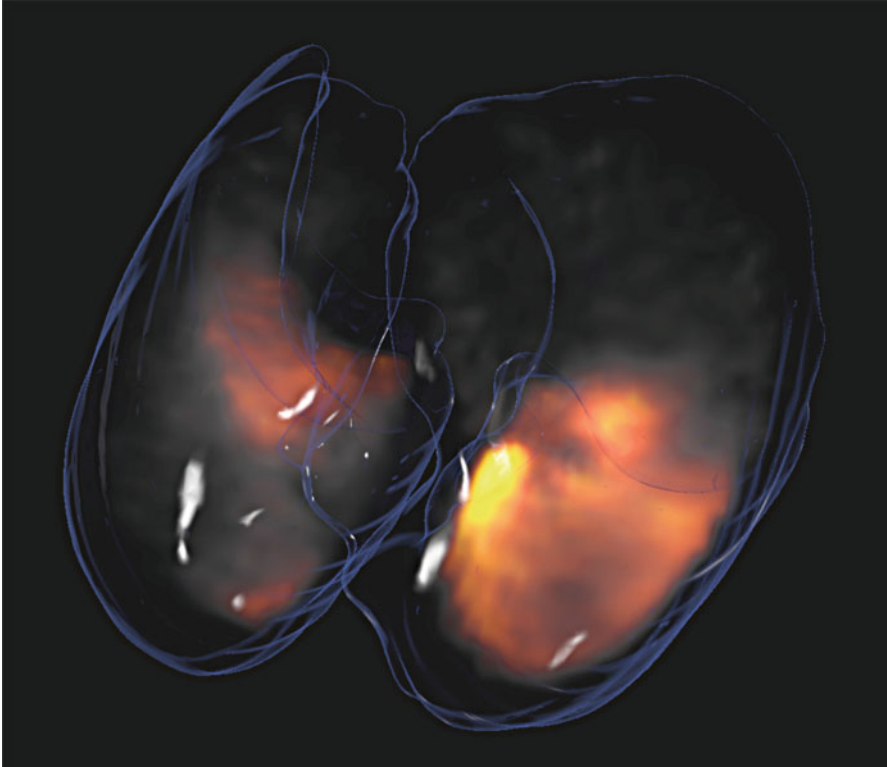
Gas trapped in the lungs during an asthma attack. The regional concentration of the gas shows that severe airway narrowing or closure during an asthma attack is highly clustered in some regions of the lungs while regions remain relatively well-ventilated. The gas concentration in the lungs is visualized with a color scale that is fully transparent for low values and shows increasing concentrations in red, yellow, and white for the highest. The lungs are visualized like glass with a blue glow. The three-dimensional rendering is based on imaging data from a study using positron emission tomography and computer tomography (PET-CT) to investigate the effects of asthma attacks on regional ventilation
